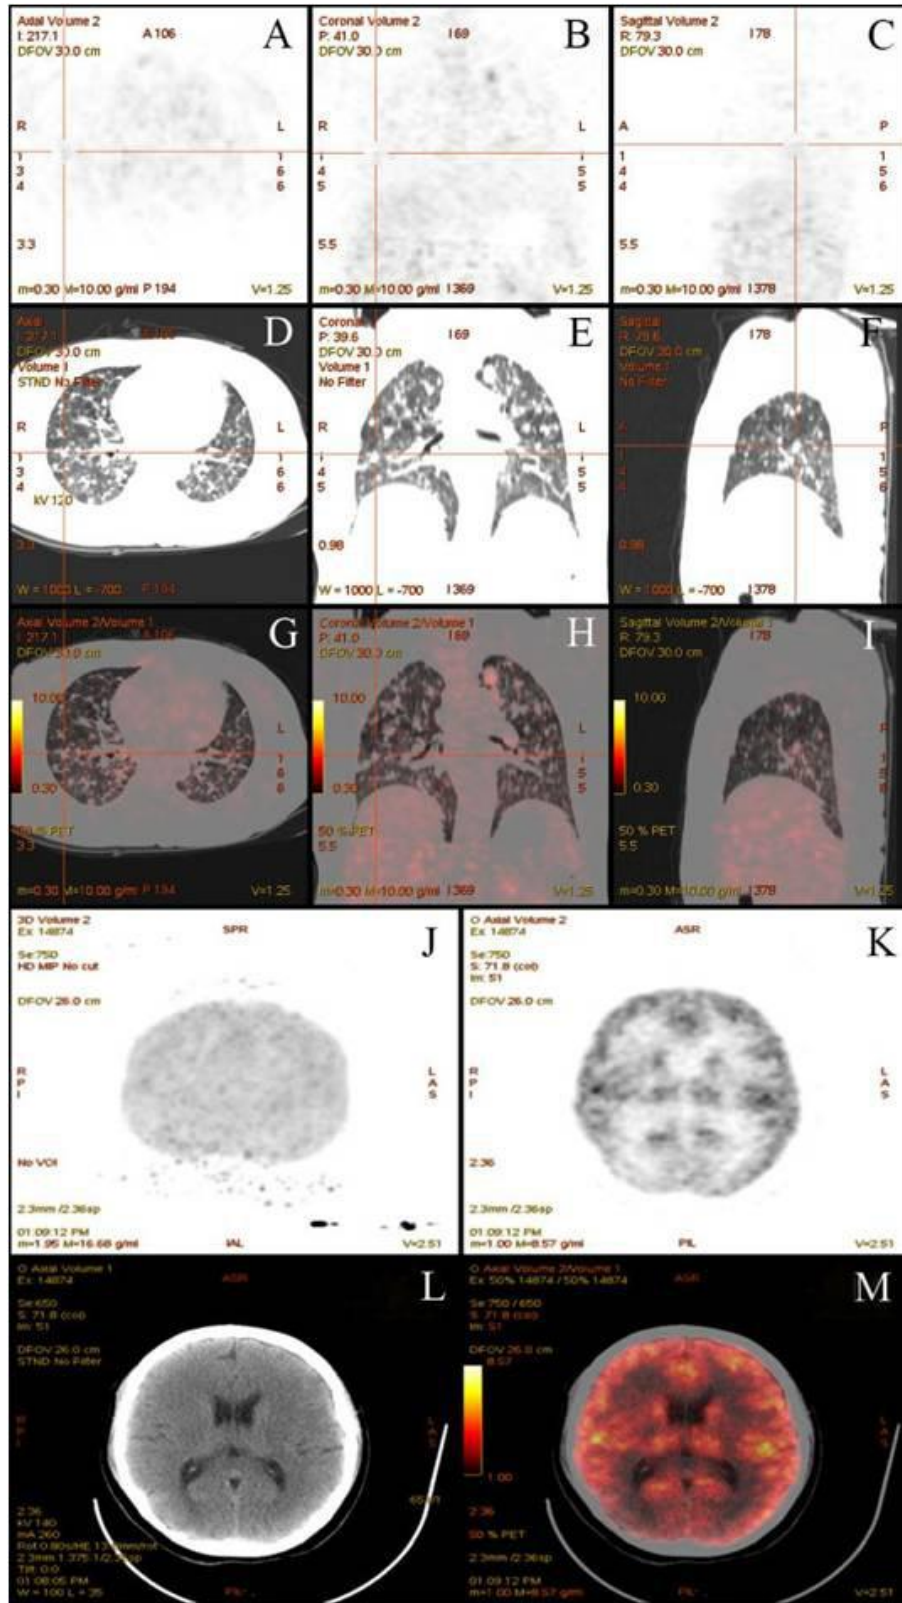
Positron emission tomography-CT (PET-CT)
